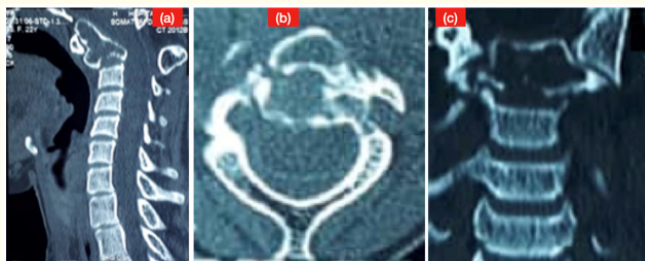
Reconstructed sagittal (a), axial (b) and coronal (c) CT images showing a contrast-enhancing lytic lesion of the insufflated type with a punched-out appearance, thin sclerotic rim and endosteal scalloping measuring 14 mm x 21 mm located in the C2 odontoid process. The margins of the lesion were preserved without erosion. No calcification or associated soft tissue mass were present.
